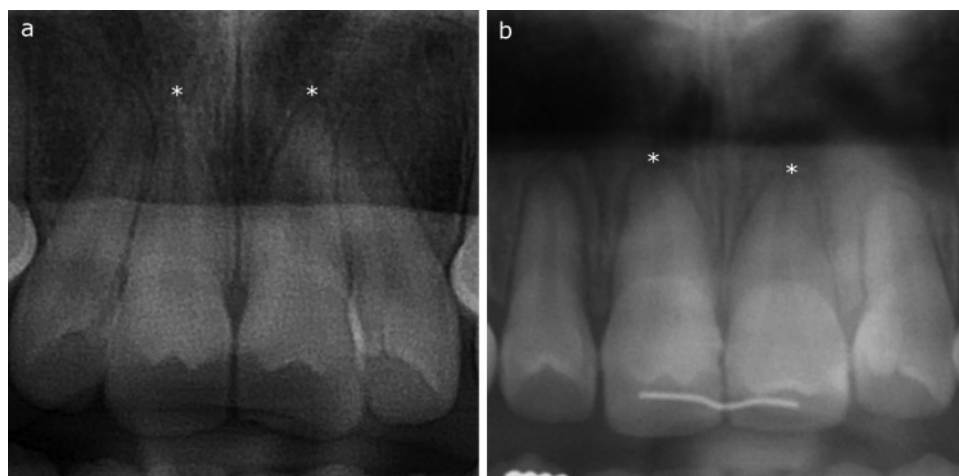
Pretreatment (a) and posttreatment (b) panoramic radiographs of a 12-year-old female with bimaxillary protrusion who experienced moderate root resorption of her maxillary incisors during orthodontic treatment.
